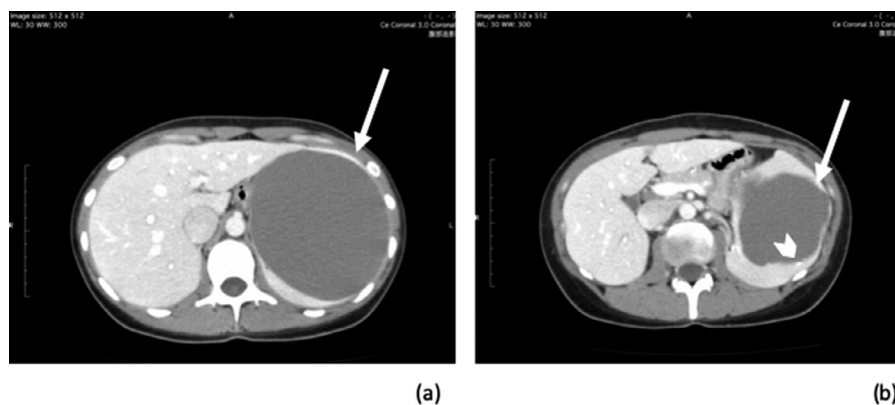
Computed tomography scan showing a large cyst in the upper lobe of the spleen (arrow) (a, b) with partial wall calcification (arrowhead) (b).
